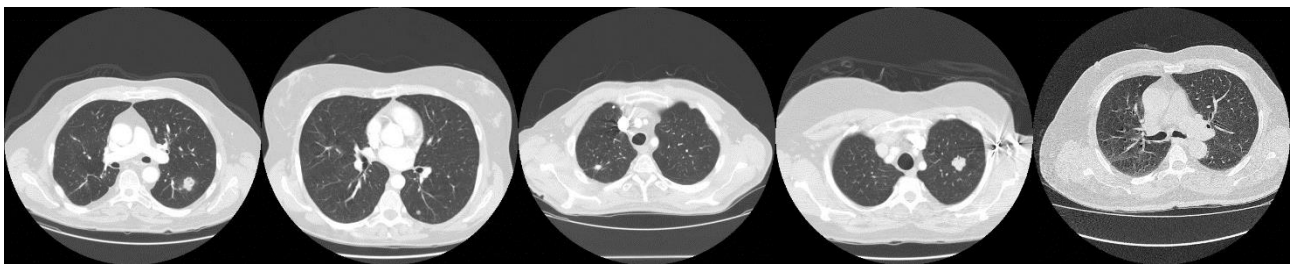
Dataset CT-images samples.
